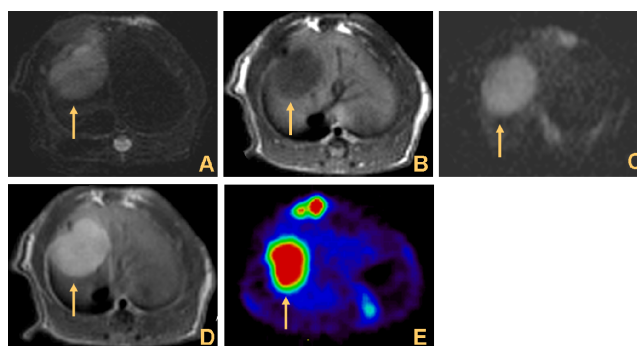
Baseline images before ZD6126 treatment. The tumor showed homogeneous hyperintensity on T2WI (A) and ADC (C), hypointensity on T1WI (B), and homogeneous enhancement on CE-T1WI (D). High uptake of FDG in tumor was observed on micro-PET (E).
